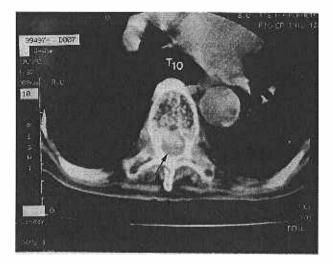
CT scan of Case 2 at T10 showing a posterior extra-thecal soft tissue mass displacing the cord anteriorly (arrow). Again note the absence of bony destruction.
